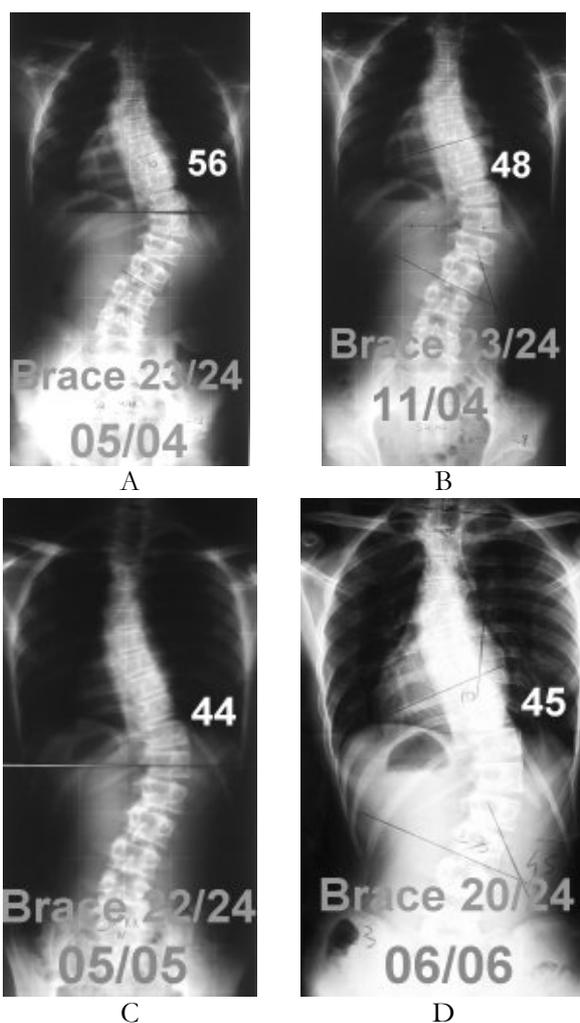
Case history of Maria. In each radiograph month and year are represented, as well as Cobb degrees, Risser (R) stage and years (y). Bracing time is shown: 23/24 means 23 hours per day; PE: Physical Exercises treatment.
